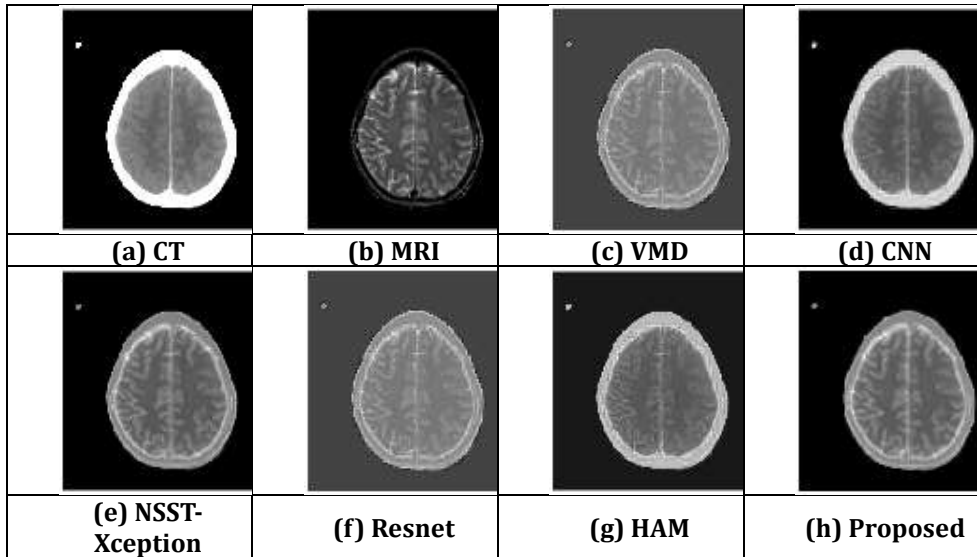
Visual analysis of various methods for CT-MRI-T1 (fatal stroke)
